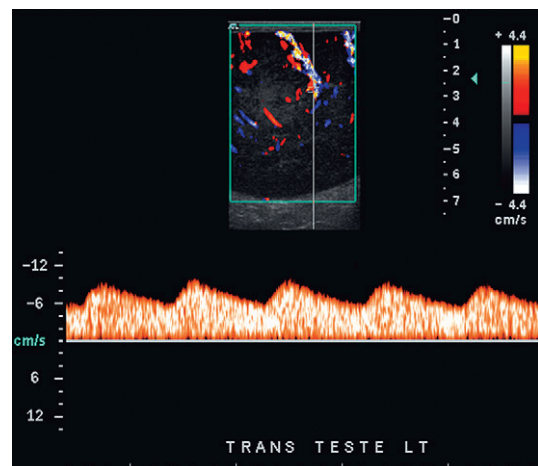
Spectral Doppler tracing of an area of testicular inflammation. Flow during diastole is relatively brisk resulting in a resistive index of <50%. This appearance is consistent with inflammatory hyperaemia.
